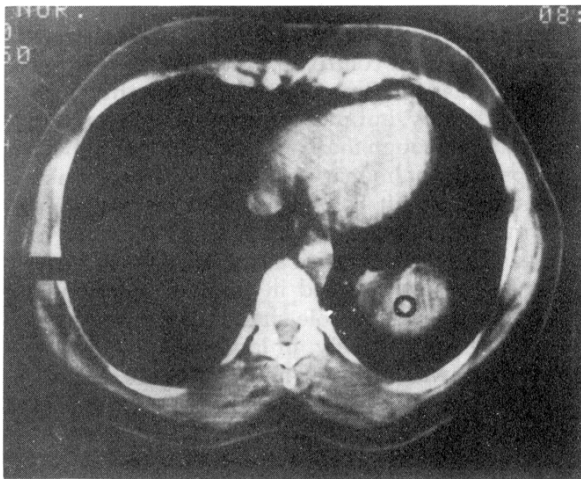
Computed tomographic scan showing the tumour.
